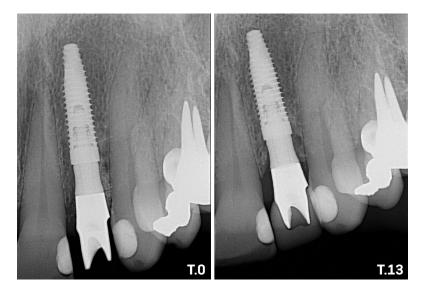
Periapical Xray of a Grand Morse® implant with 13 months of follow up.
